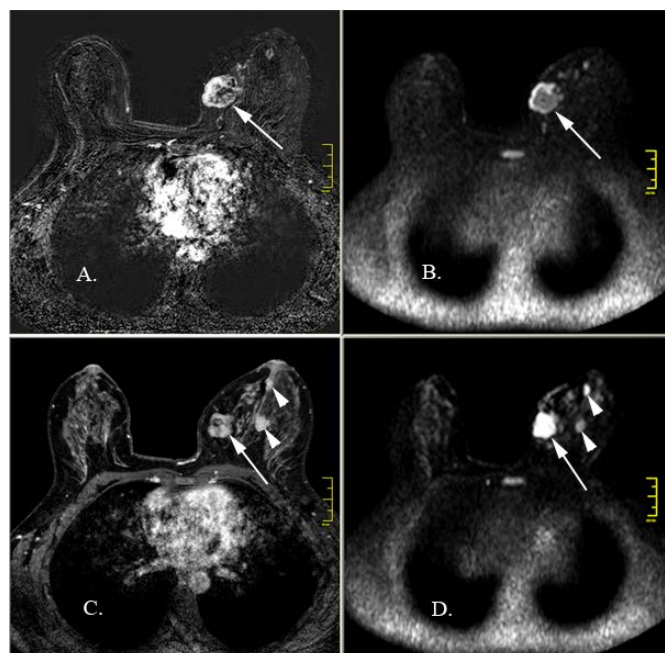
A 44-years-old patient presented with a large palpable mass in the left breast localized at the union of her left internal quadrants. The ultrasound examination raised suspicion for multiple lesions. MRM found a 38 mm suspicious nodule (arrows) showing an inhomogenous rapid contrast uptake on subtraction images (A). This lesion has a high signal on T2 images and a low signal on T1 ones suggestive for a fluid content. This is confirmed by DWIBS (B) that shows intense restriction on the lesion borders. Several similar nodules (arrow) were found both on THRIVE (C) and DWIBS (D). The pathological exam revealed mucinous carcinoma in all revealed nodules.
